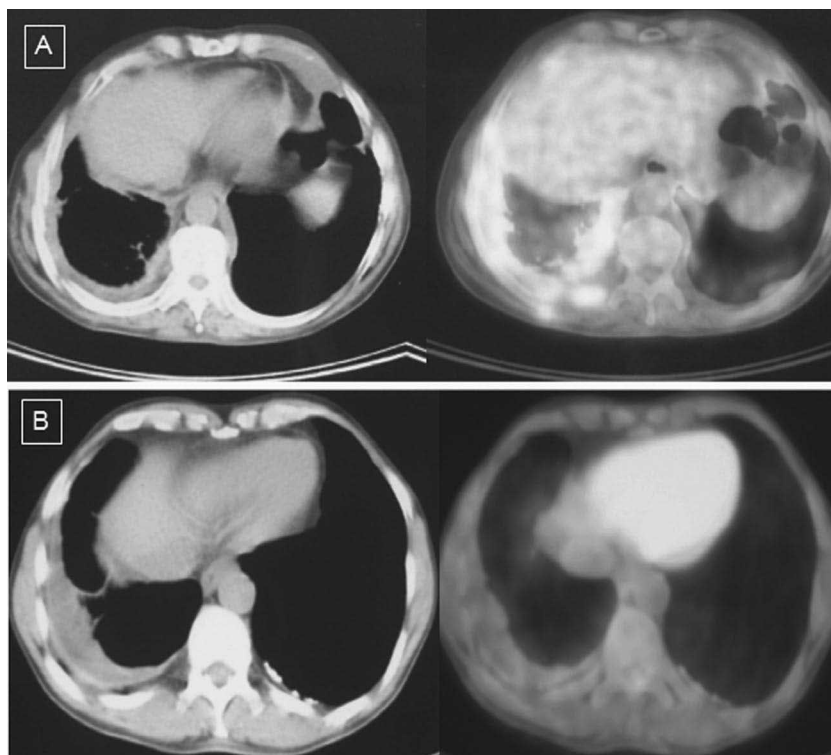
In patients with malignant mesothelioma, transverse FDG imaging revealed extensive pleural involvement of the right pleura with a maximal standardized uptake value of 6.25 (A, top). In a case of a benign pleural lesion, PET imaging revealed an absence of FDG uptake within the pleura, and this image suggests the benign nature of this lesion (B, bottom).
